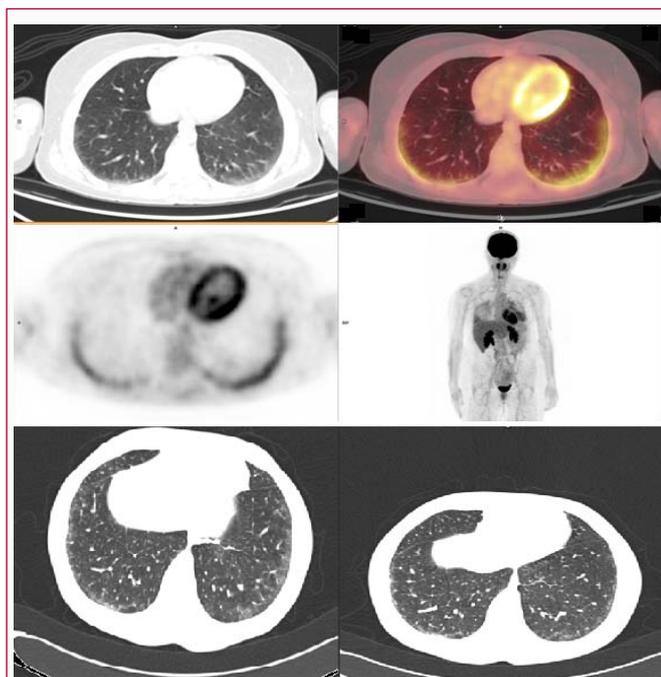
(A) 2- ^{18}F FDG PET/CT (July/2019) shows pathological uptake of moderate intensity in the posterior segments of both lower lobes that coincide with a very discrete interstitial pulmonary involvement of peripheral and basal predominance, suggestive of pathology active inflammatory, to rule out PID. (B) HRCT (August/2019) of the chest showed interstitial lung involvement with a reticular pattern and ground glass, predominantly peripheral and basal, suggestive of ILD. (C) Control CT (October/2020) showed improvement in the predominantly peripheral and basal interstitial lung involvement.
